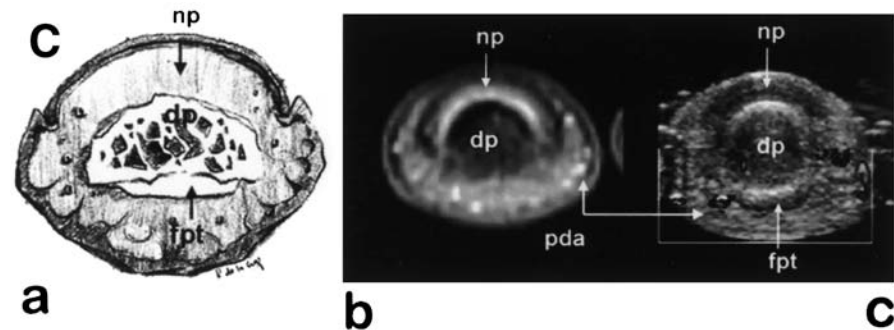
Axial anatomic images at the levels A, B, and C of Fig. 1a (proximal, middle, and distal phalanges, respectively). a Axial image. b Fast spin-echo proton-density (FSE PD) fat-suppressed MR image (TR/TE/slice thickness: 3000 ms/43 ms/4 mm). c Axial ultrasound image
